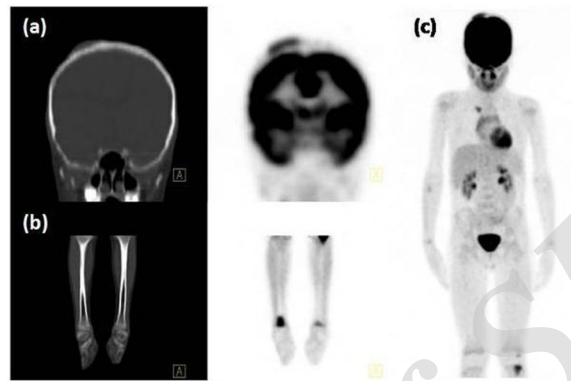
FDG PET/CT was performed with a dedicated PET/CT scanner (Biograph LSO HI-REZ PET/CT; Siemens, Medical Solutions, Knoxville, TN, USA) as a part of staging before treatment in a 8-year-old boy with cutaneous B-cell Lymphoblastic Lymphoma and coronal image of the head showed high FDG uptake in the scalp with maximum standardized uptake value (SUVmax) of 7.61 (a). The Maximum Intensity Projection (MIP) presentation of the staging PET/CT examination demonstrating multiple bone metastases with increased FDG uptakes (SUVmax: 4.10) and the FDG uptakes in tibias are also seen (b, c).
